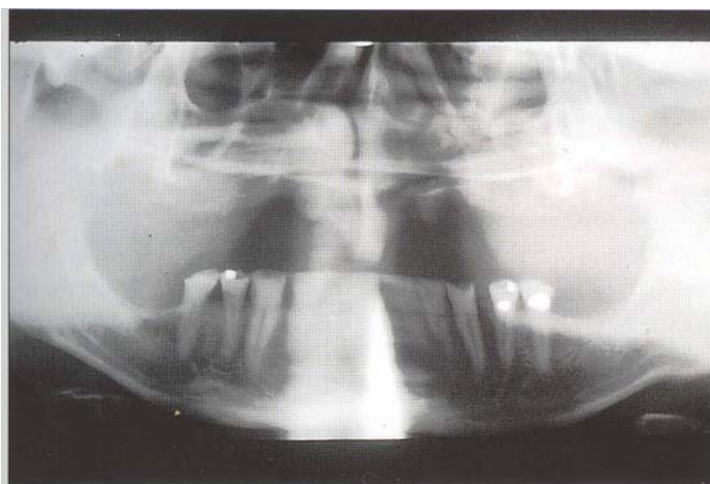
3c Panoramic radiograph showing the intact anterior mandibular teeth without posterior occlusion, resulting in severe anterior maxillary atrophy.
